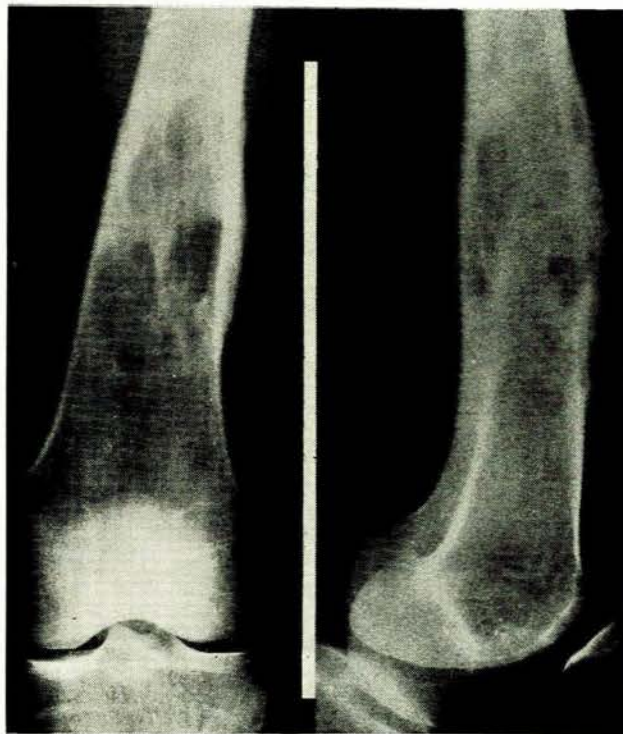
X-ray examination of the left femur. Diagnosis—osteogenic sarcoma—29.9.59.
